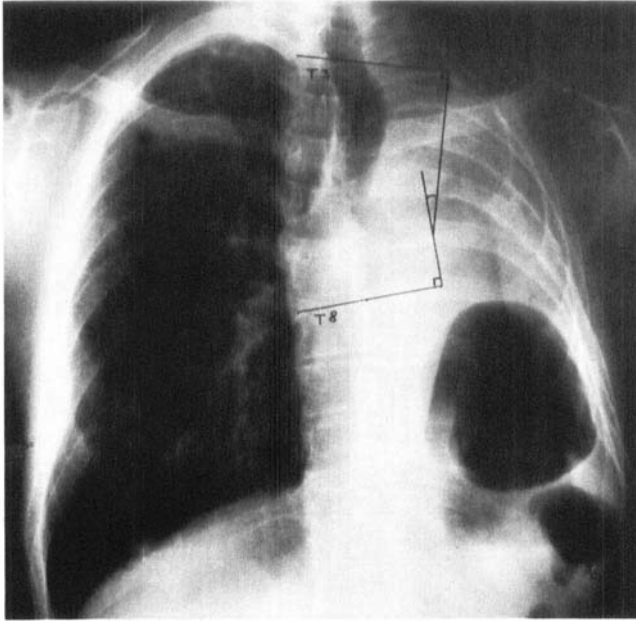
Typical X-ray of a patient who had undergone pneumonectomy on the left side. Severe changes as a result of shrinkage of the pneumonectomy cavity can be clearly seen. The angle of the scoliosis is superimposed.
